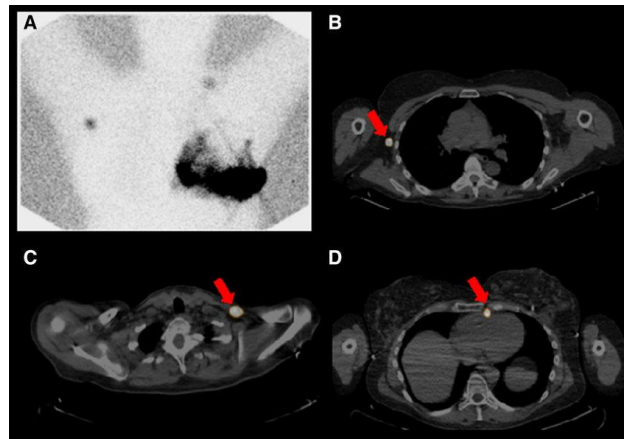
Single Photon Emission Computed Tomography results example.
